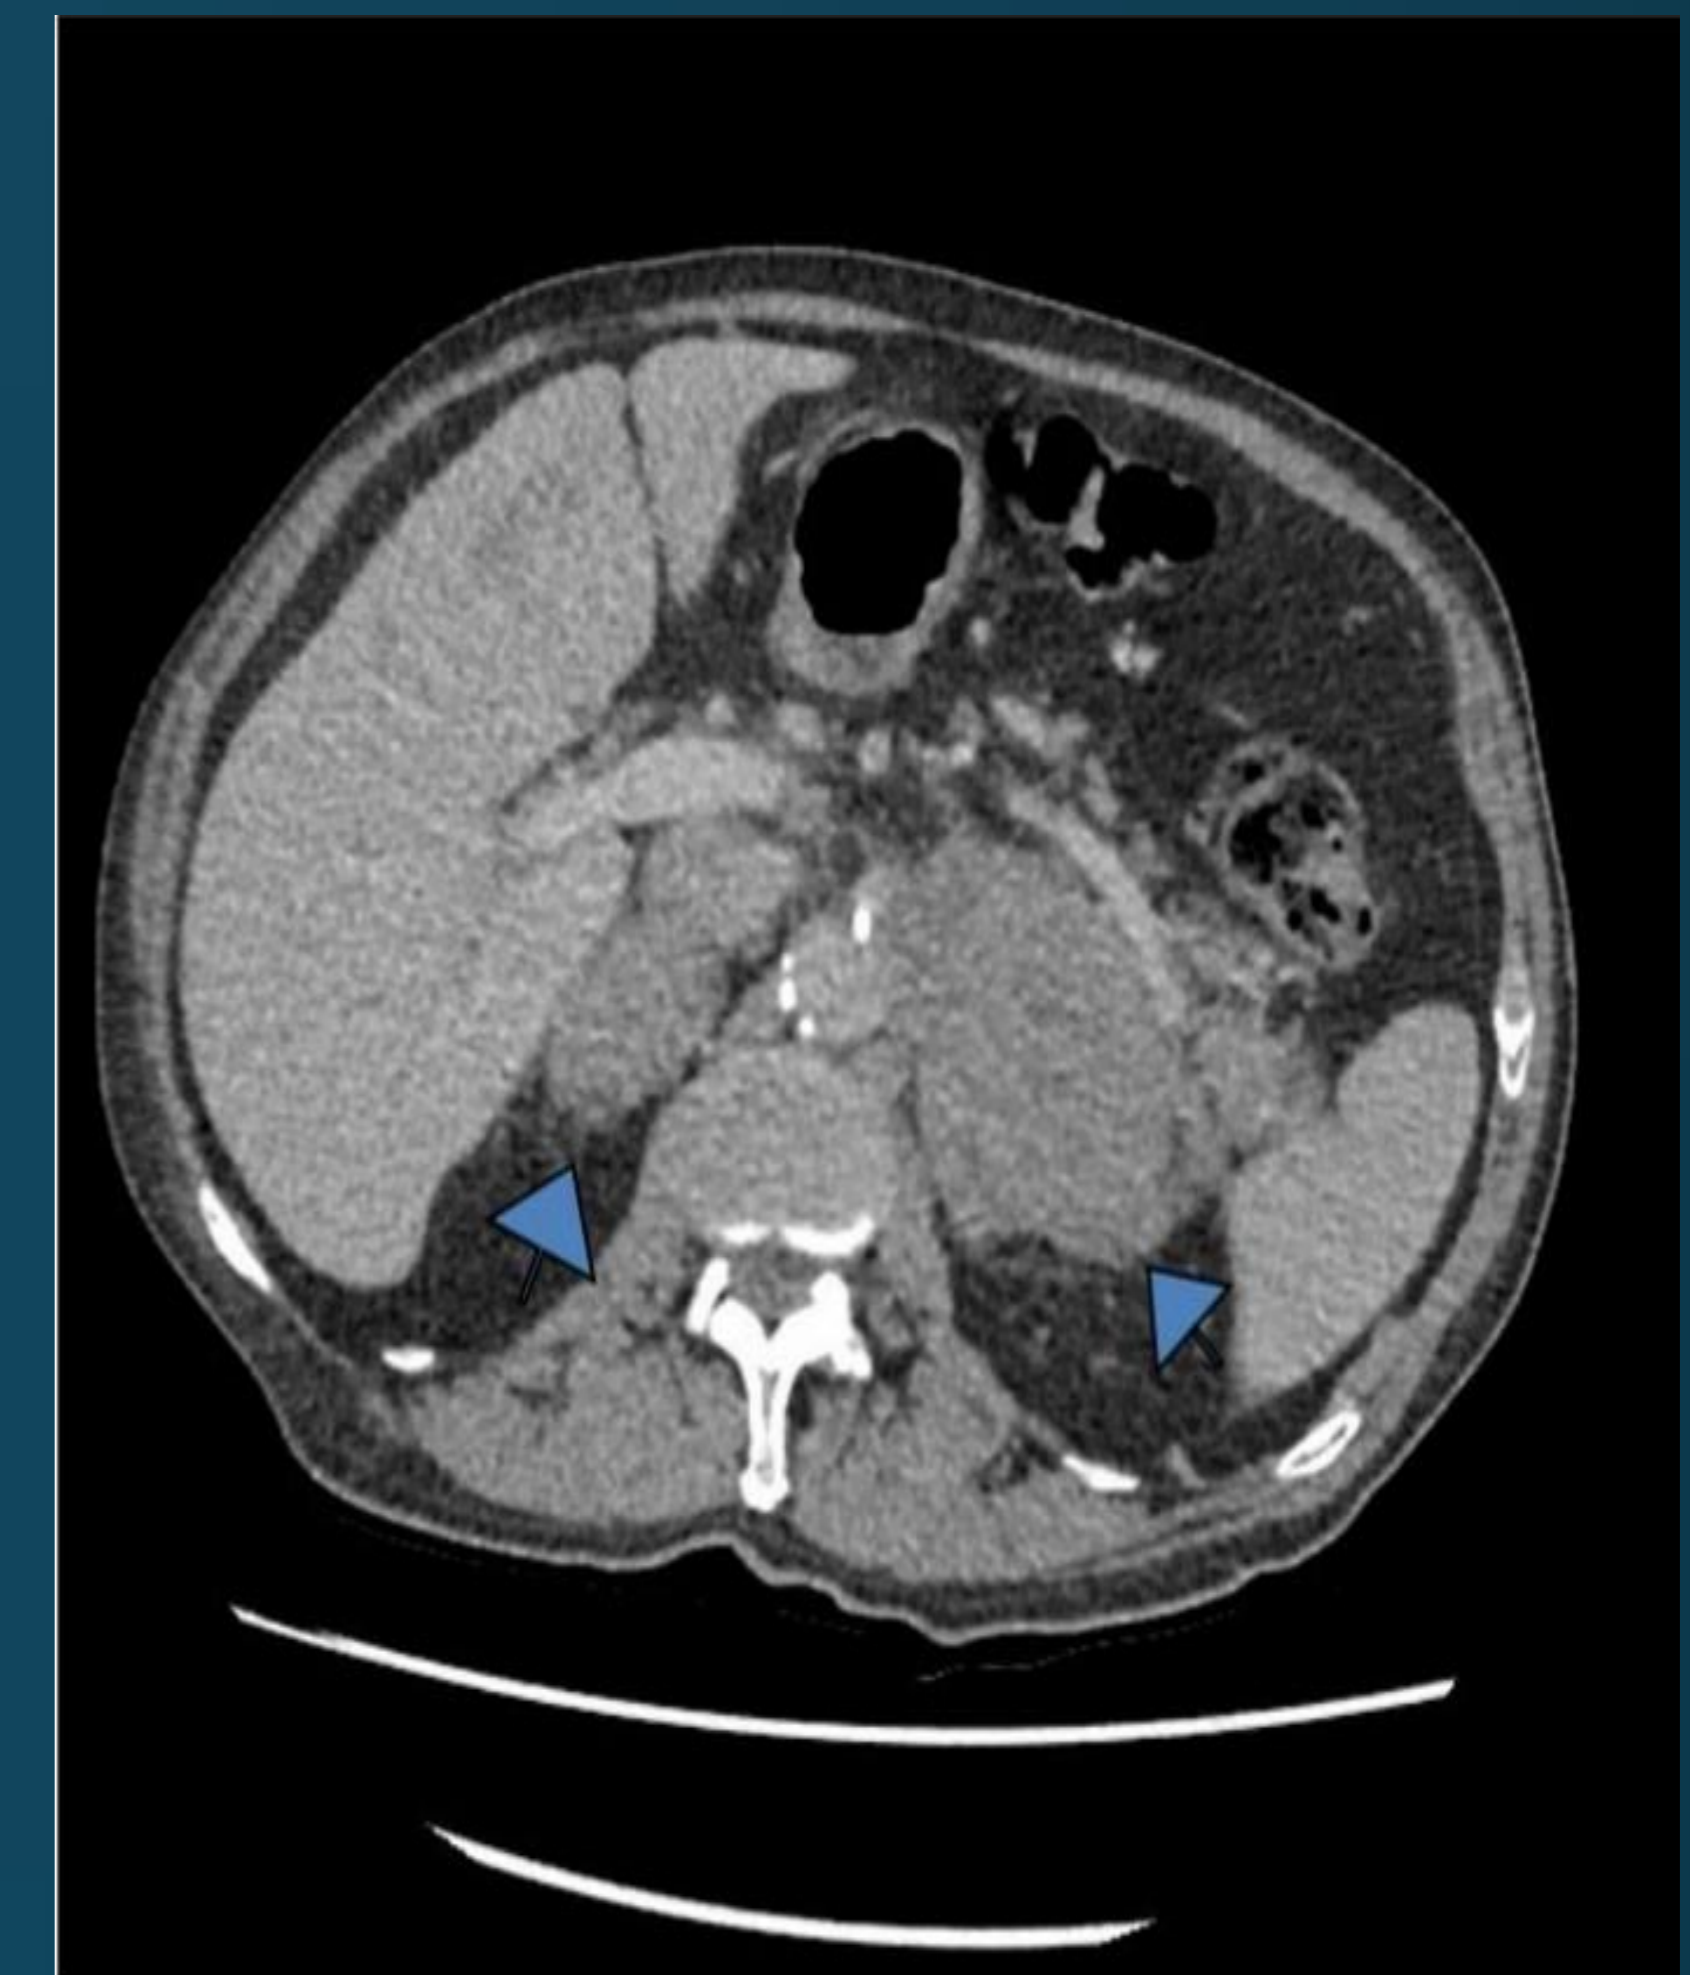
CT scan: adrenal masses
